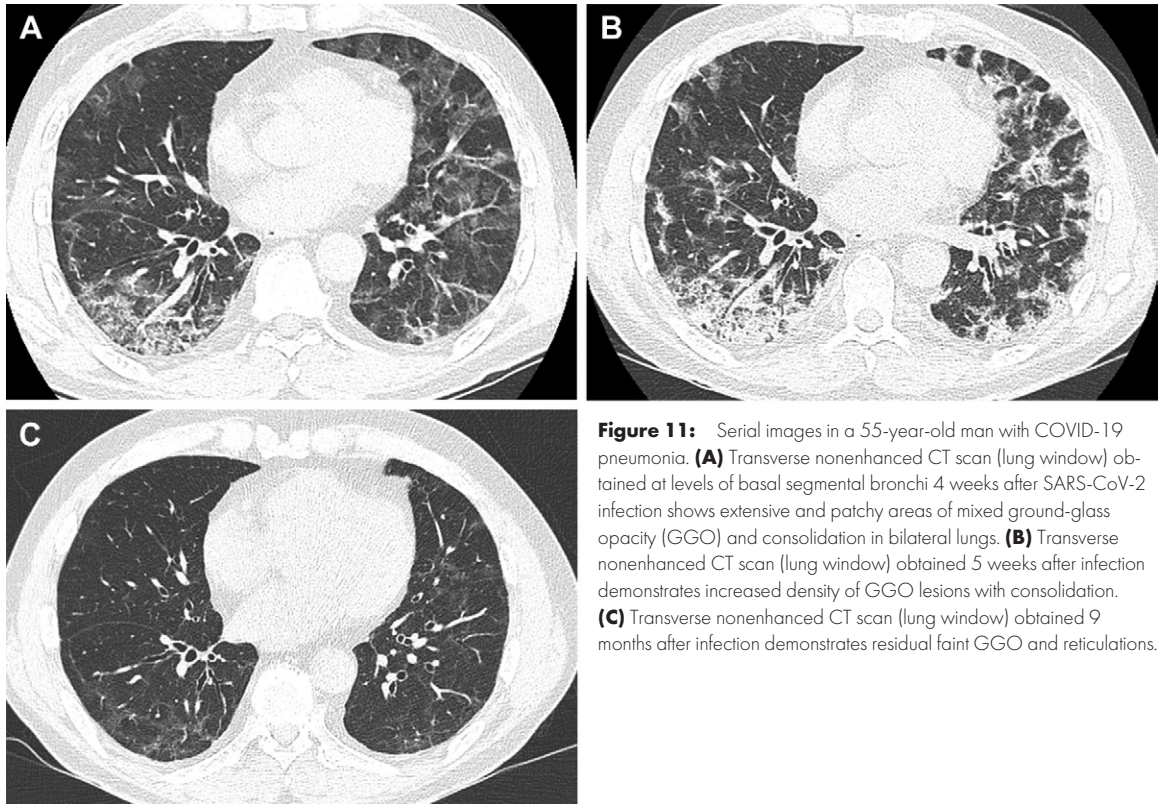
Serial images in a 55-year-old man with COVID-19 pneumonia. (A) Transverse nonenhanced CT scan (lung window) obtained at levels of basal segmental bronchi 4 weeks after SARS-CoV-2 infection shows extensive and patchy areas of mixed ground-glass opacity (GGO) and consolidation in bilateral lungs. (B) Transverse nonenhanced CT scan (lung window) obtained 5 weeks after infection demonstrates increased density of GGO lesions with consolidation. (C) Transverse nonenhanced CT scan (lung window) obtained 9 months after infection demonstrates residual faint GGO and reticulations.
